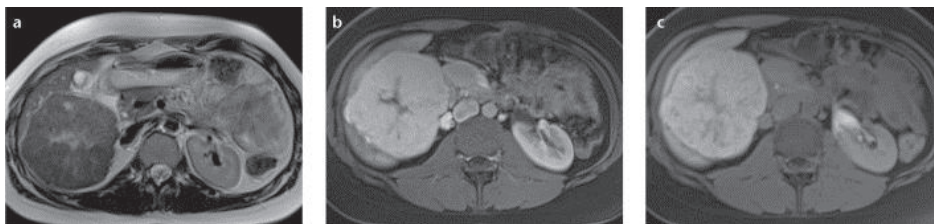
/b/c. Axial T2-weighted (a), venous phase T1-weighted (b), and 20-min T1-weighted (c) MR images of a patient with the “spoke wheel” aspect that is typical for FNH. A central scar with divergences to the periphery is visible on T2-weighting and is reminiscent of a “spoke wheel” (a). These so-called spokes are normally enhanced in the venous phase using a nonspecific contrast agent or gadobenate dimeglumine. However, when using gadoxetate disodium, the central scar and the spokes are hypointense due to pseudo washout (b). After 20 min, the majority of the lesion (except the scar) becomes hyperintense due to internal bile duct proliferation (c).
